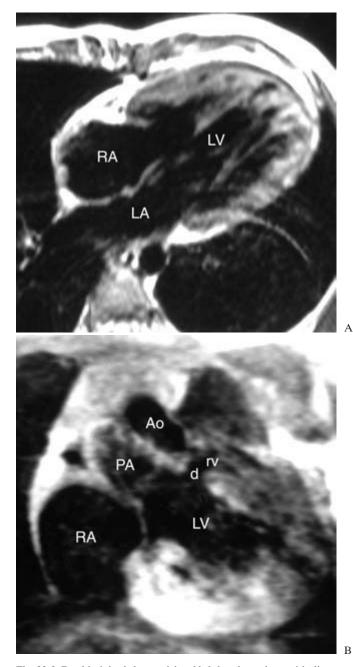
Double-inlet left ventricle of left-hand topology with discordant ventriculoarterial connection. A. Axial MR image shows both right atrium (RA) and left atrium (LA) connected to the left ventricle (LV). B. Coronal MR image demonstrates the rudimentary right ventricle (rv) located at the superior and left corner of the left ventricle. The ventricular septal defect (d), which is a part of the subaortic outflow tract, is very restrictive. Ao, ascending aorta; PA, pulmonary artery.
